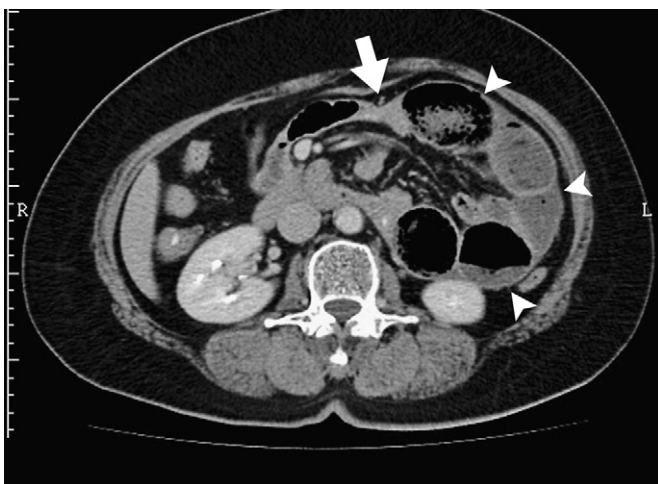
Axial contrast-enhanced computed tomography image shows a saclike dilated jejunum (arrows) prolapsing through the left paraduodenal fossa, with the inferior mesenteric vein (arrowheads) in the neck of the hernial sac displaced anteriorly by the hernial bowel loops.
